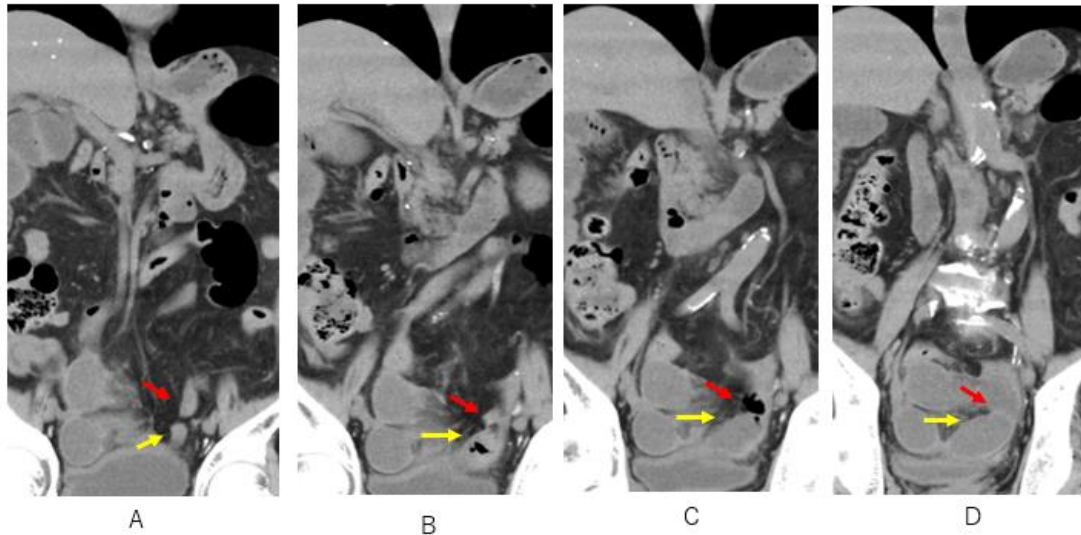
There is a double knot sign on coronal CT; red oral sided knot indicates connection between oral sided bowel and closed-loop dilated bowel (A-D); yellow anal sided knot indicates connection between closed-loop dilated bowel and anal-sided constrictive bowel. Note mesenteric edema heads to double knot.
